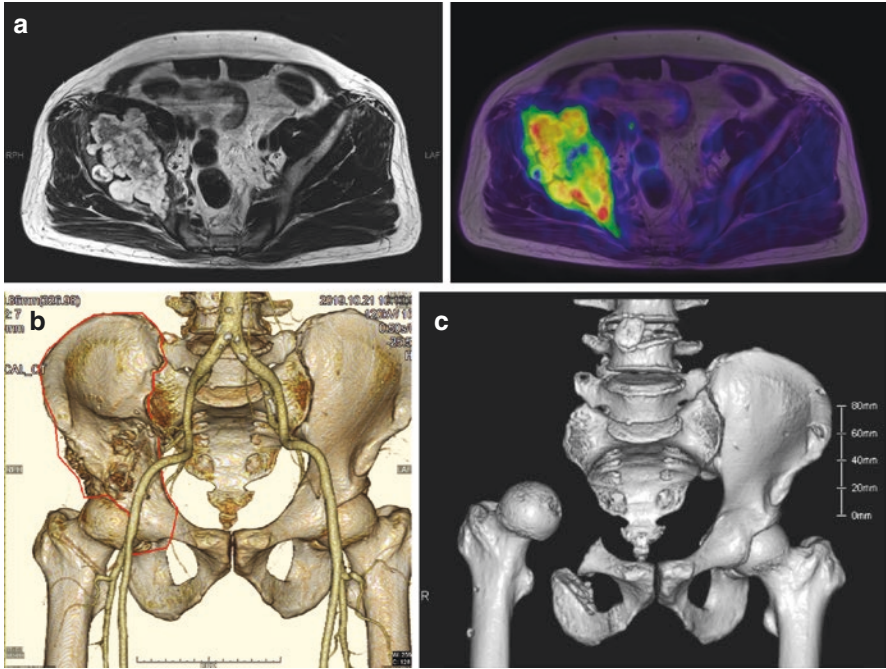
Chondrosarcoma of the right pelvis. (a) T2-weighted MRI showing right pelvic bone tumor expanding with a lobulated structure. PET/MRI showing abnormal F-18 FDG accumulation in the tumor. (b) Three-dimensional CT angiography showing intact right external iliac artery and planned excision range. (c) Postoperative 3D-CT scans showing hip transposition where the tumor was removed
